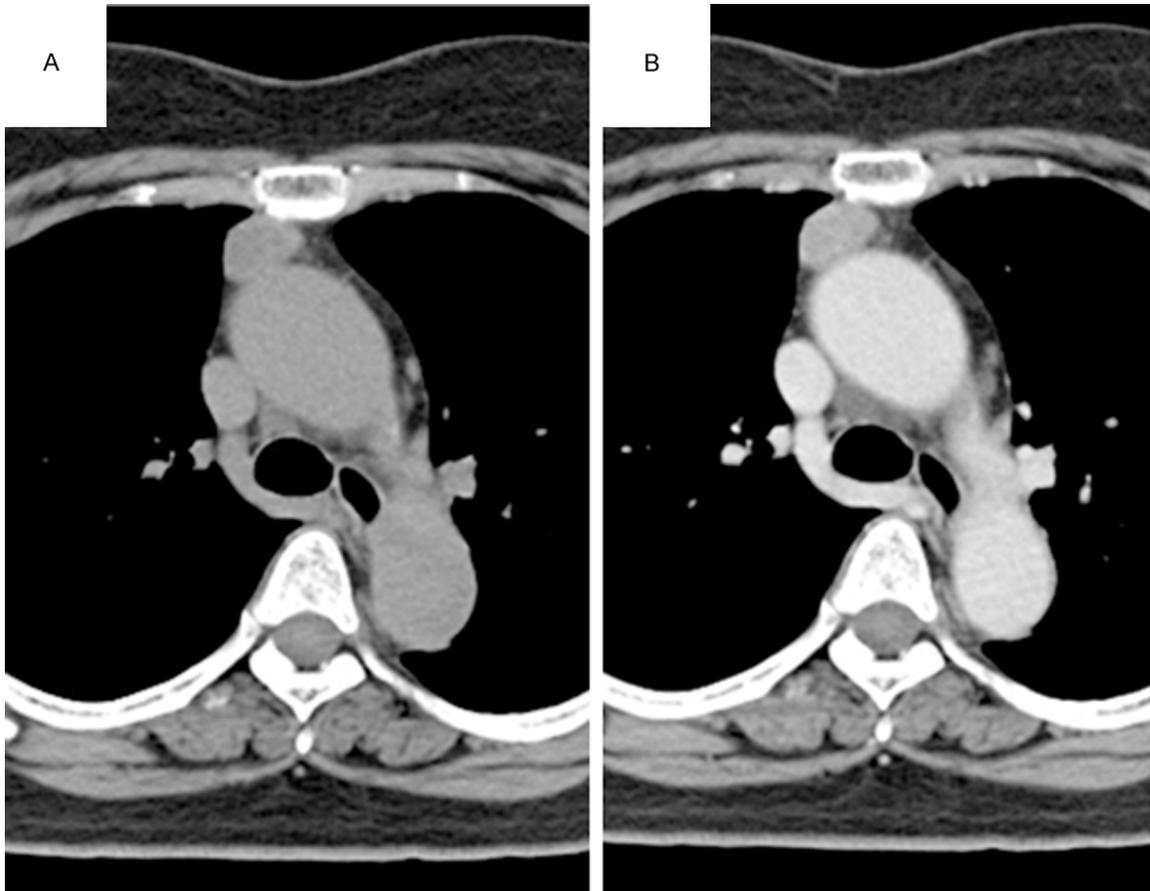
Computed tomography scan. A. A well-circumscribed anterior mediastinal mass was identified, measuring 31 × 24 × 17 mm. B. The mass was moderately contrast-enhanced.
